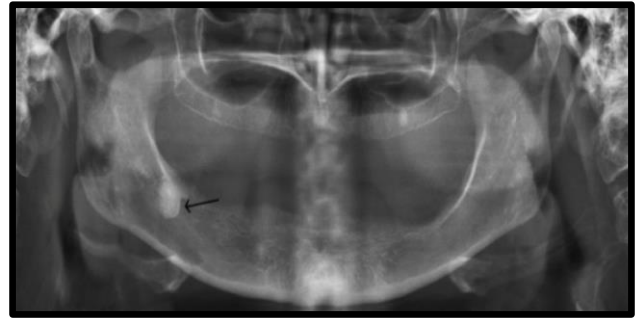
Panoramic radiograph evaluating bone resorption after denture fabrication
